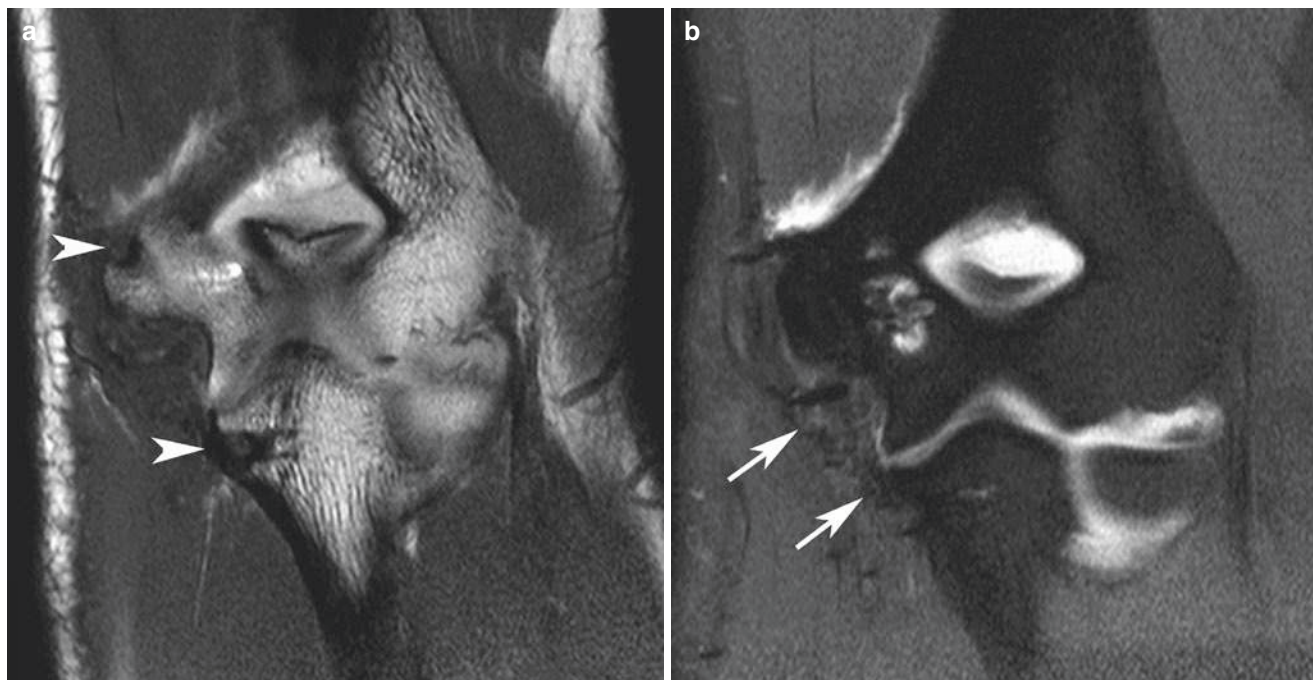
Intact UCL reconstruction in 27-year-old professional baseball pitcher. (a, b). Coronal T1-weighted arthrographic images without (a) and with fat suppression (b) show the osseous tunnels (arrowheads)
